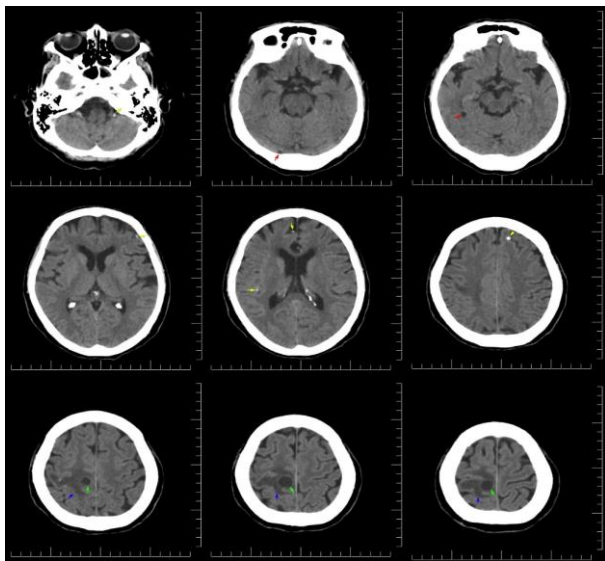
Cranial CT scan showing nonspecific punctate left occipital, bilateral frontal, and right parietal calcifications
